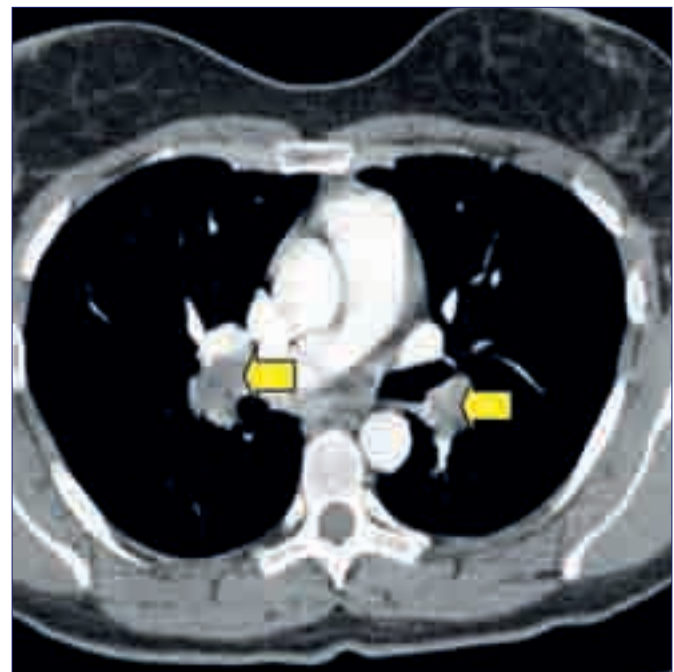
CT pulmonary angiogram of patient showing bilateral pulmonary emboli with filling defects (yellow arrows)
